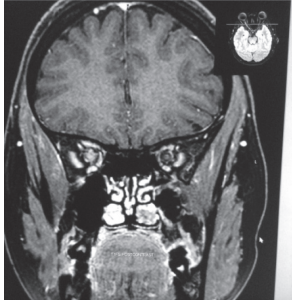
MRI T1FS coronal sequence showing enhancement of bilateral optic nerves after contrast.
